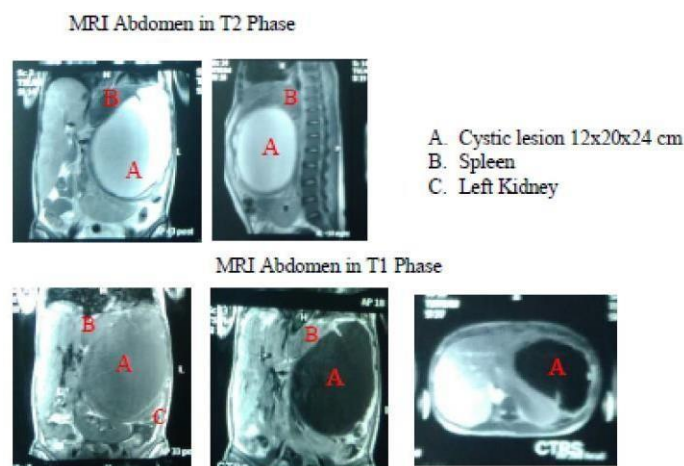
MRI of the patient's abdomen without and with contrast
